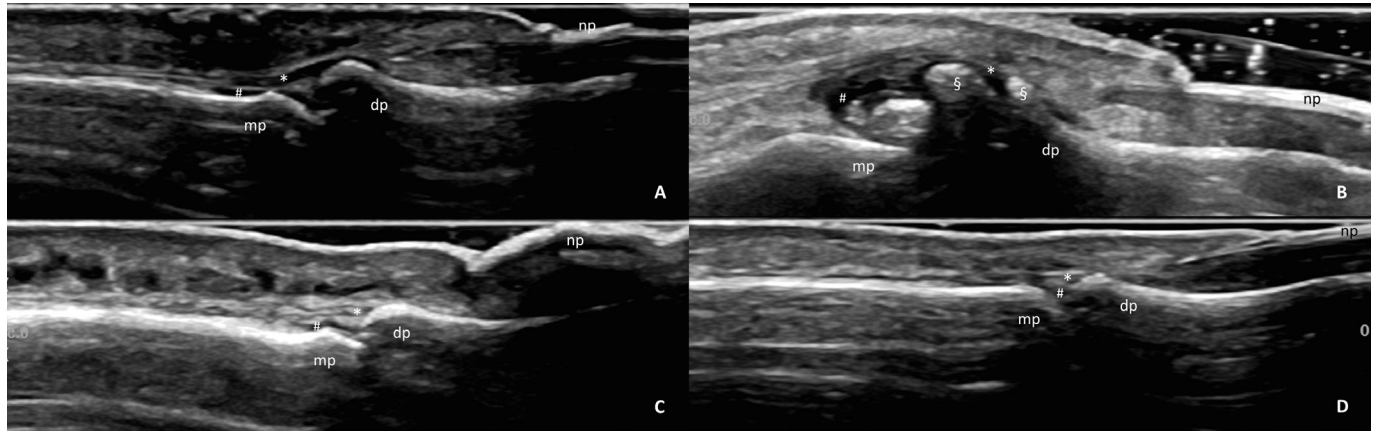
Ultrasonographic image of the synovio-enthesal-complex. Dorsal longitudinal scan. (A) Patients with psoriatic arthritis with loss of normal fibrillar architecture at extensor tendon insertion (*) at DP and effusion at the distal interphalangeal joint (#). (B) Patient with osteoarthritis with severe new bone formation (§), effusion and synovial hypertrophy of the NP. (C) Patients with skin psoriasis with severe thickening and loss of trilaminar structure of the NP. (D) Healthy control demonstrating normal fibrillar architecture of the extensor tendon (*) and a healthy NP with trilaminar structure as two hyperechoic lines surrounding an anechoic line. DP, distal phalanx; MP, medial phalanx; NP, nail plate.
